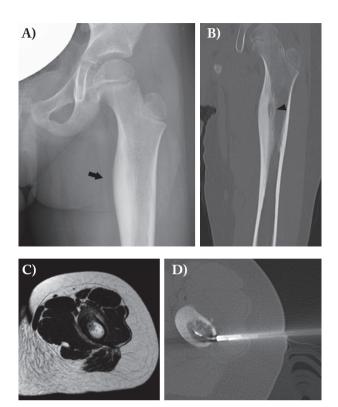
Osteoid osteoma of the proximal left femur. 6 year old female with left thigh pain of recent onset with no history of trauma. (A) Standard X-Ray shows wide cortical thickening of the medial portion of the proximal femoral diaphysis (arrow); radiolucent *nidus* is partially obscured by the surrounding reactive sclerotic bone. (B) MPR coronal view CT scan clearly demonstrates the presence of an oval shaped radiolucent *nidus* with some degree of calcification inside (arrowhead). (C) T2-weighted MRI image of the same lesion on the axial plane. (D) The lesion has been effectively treated with percutaneous radiofrequency thermal ablation
